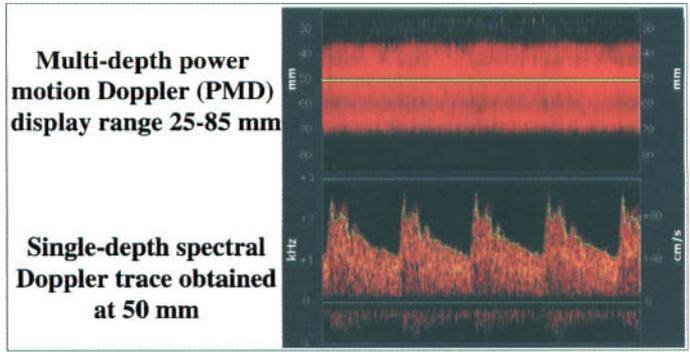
PMD/TCD display. Power-motion mode, or PMD, display combined with a single-channel transcranial Doppler (TCD) spectral analysis.
